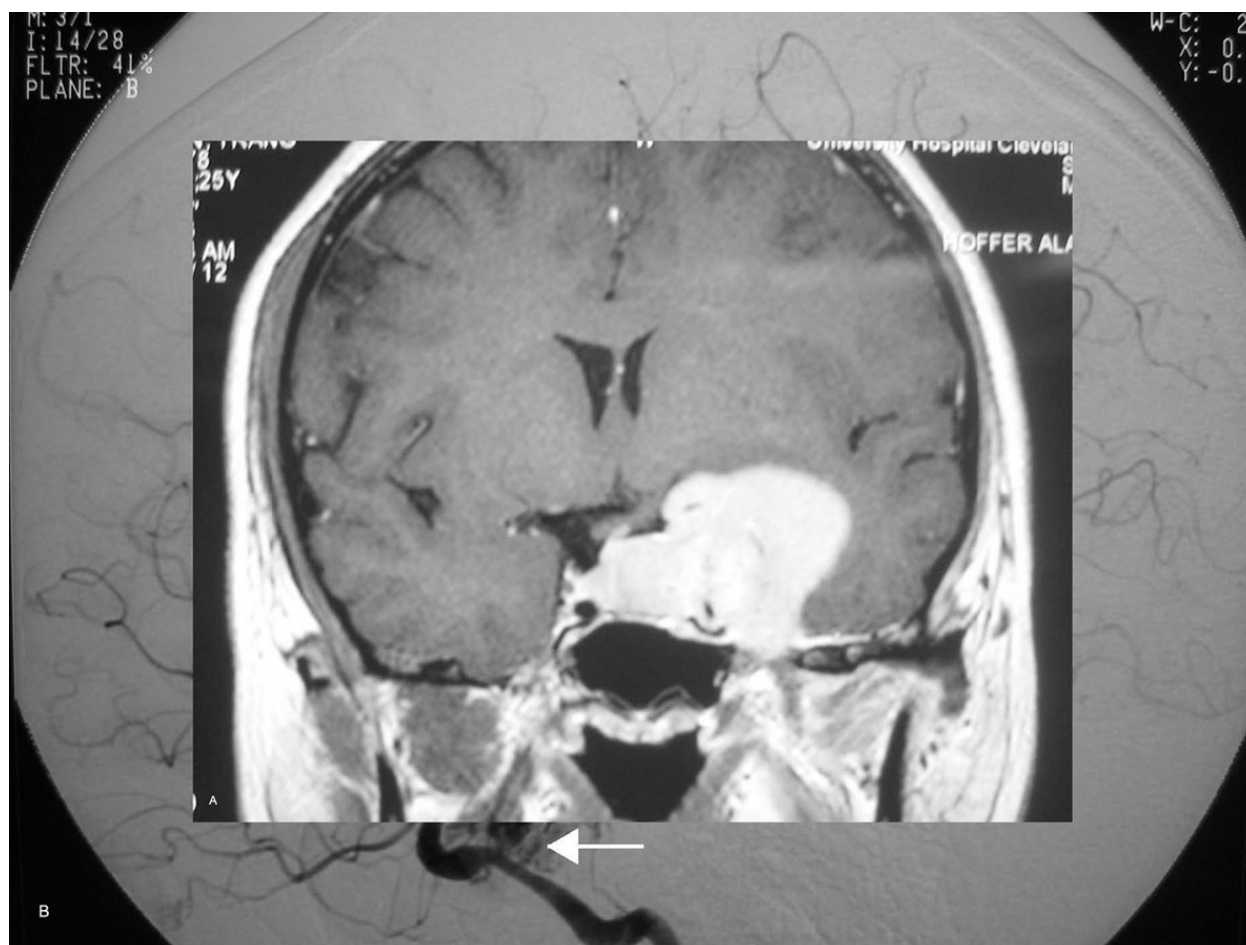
Medial sphenoid wing meningioma visualized on coronal postcontrast MRI (A). Note the involvement of the cavernous sinus in this young patient who presented with a partial third cranial nerve paresis and visual deficits. Angiography demonstrating significant tumor feeders arising directly off the petrous carotid artery (B, arrow). These were obliterated with preoperative embolization, which allowed for a subtotal resection of the tumor (C). Residual tumor is visualized deep in the cavernous sinus.
